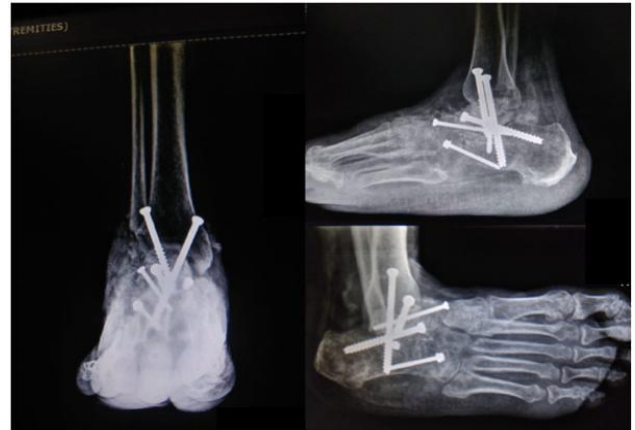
Post-operative X-ray (ankle anteroposterior, lateral and foot oblique) showing anatomically reduced joints stabilised with PTCC screws.
